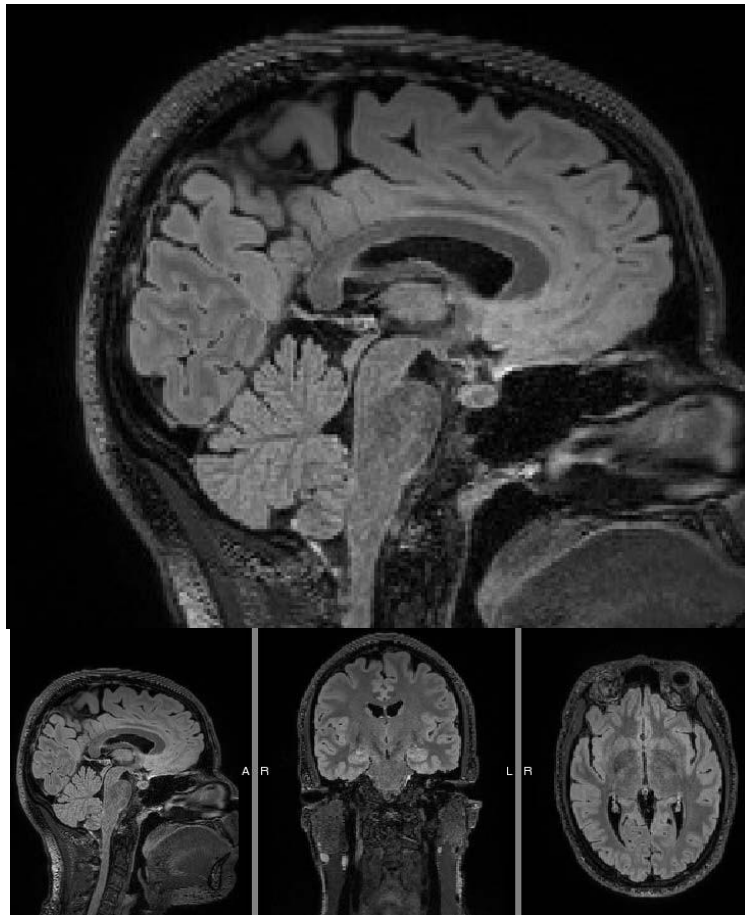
Example of 3D FLAIR
